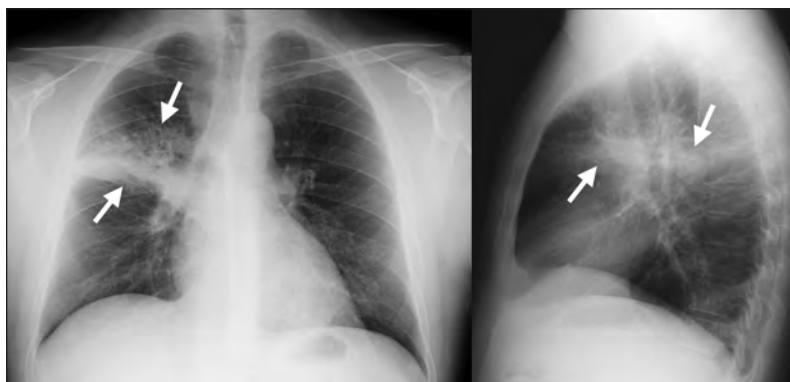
Posteroanterior and lateral radiographs of the chest of a 39-year-old man with fever, cough and pleuritic chest pain showing consolidation in the right upper lobe.
